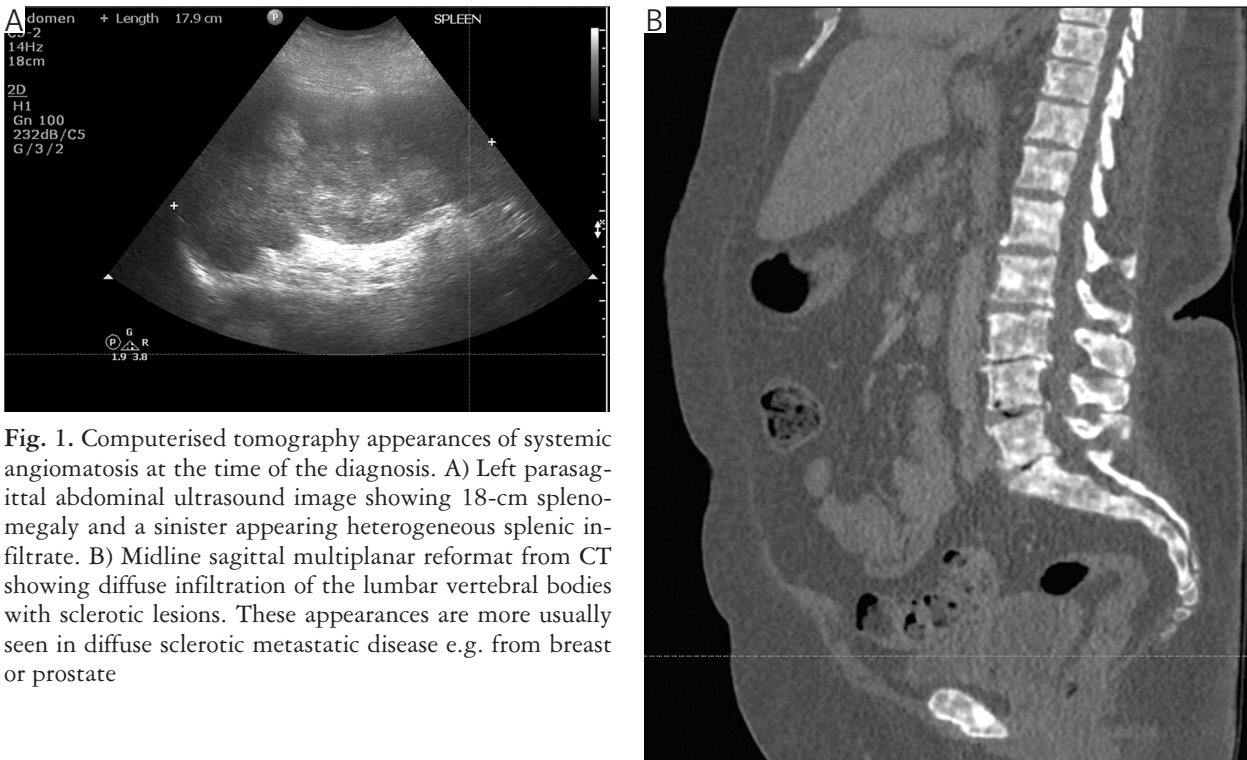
Computerised tomography appearances of systemic angiomatosis at the time of the diagnosis. A) Left parasagittal abdominal ultrasound image showing 18-cm splenomegaly and a sinister appearing heterogeneous splenic infiltrate. B) Midline sagittal multiplanar reformat from CT showing diffuse infiltration of the lumbar vertebral bodies with sclerotic lesions. These appearances are more usually seen in diffuse sclerotic metastatic disease e.g. from breast or prostate
